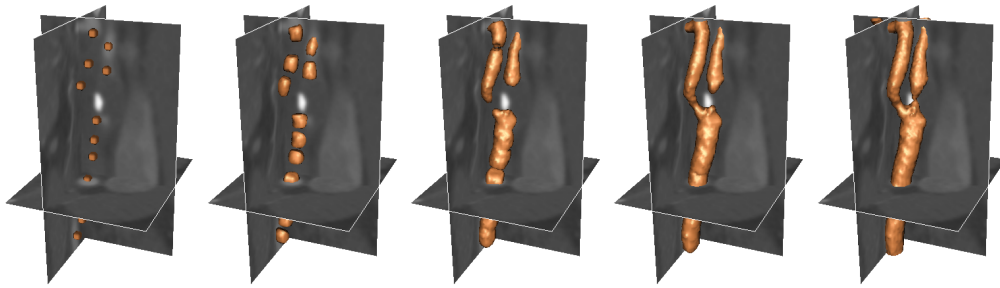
Segmentation of carotid artery from CT image dataset 3 (70x80x120) using GPF deformable model (CPU-time, 206s).
